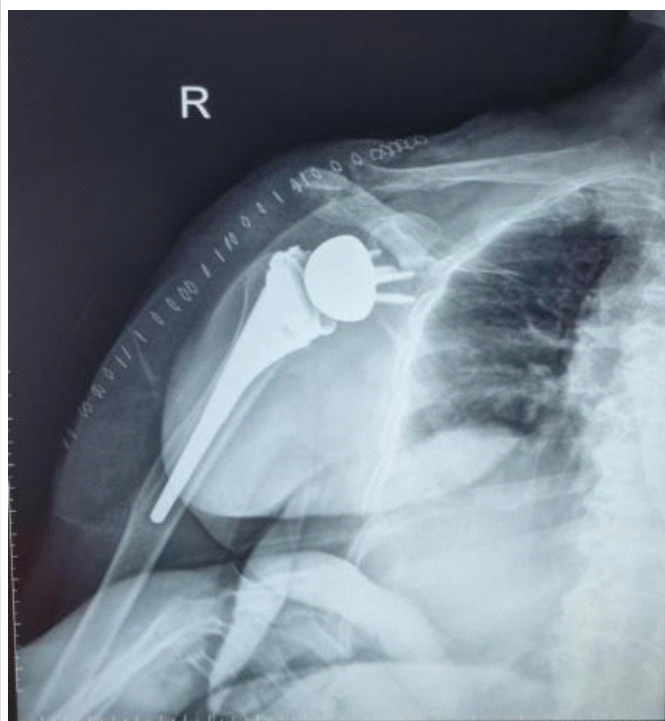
post-operative radiograph following reverse shoulder arthroplasty showing the prosthetic components in position.
